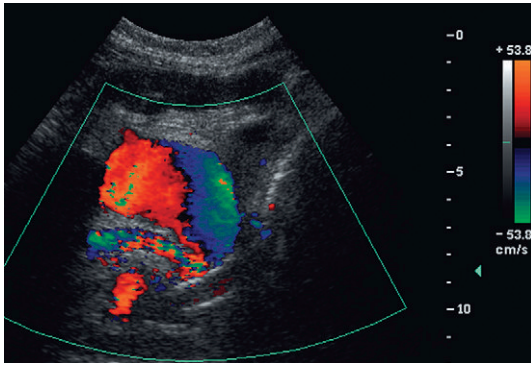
Colour Doppler image near the anastomosis of the pancreatic vascular pedicle. A rounded collection of colour flow with the classic swirl pattern identifies pseudoaneurysm of the anastomosed splenic artery.
